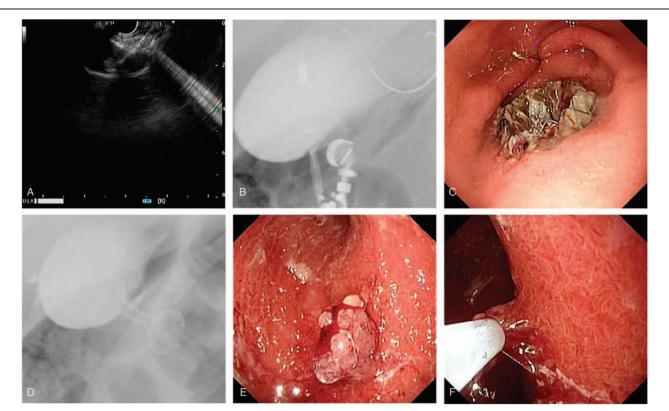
The whole procedure from endoscopic ultrasound-guided cholecystostomy to endoscopic resection of gallbladder polyps. (A) Endoscopic ultrasound-guided gallbladder puncture with echo-tip needle; (B) X-ray image of stent insertion by the electrocautery tip; (C) Endoscopic view of the released stent; (D) X-ray image of the released stent; (E) Endoscopic view of the gallbladder polyp; (F) Endoscopic view of the gallbladder polyp resection with snare.
